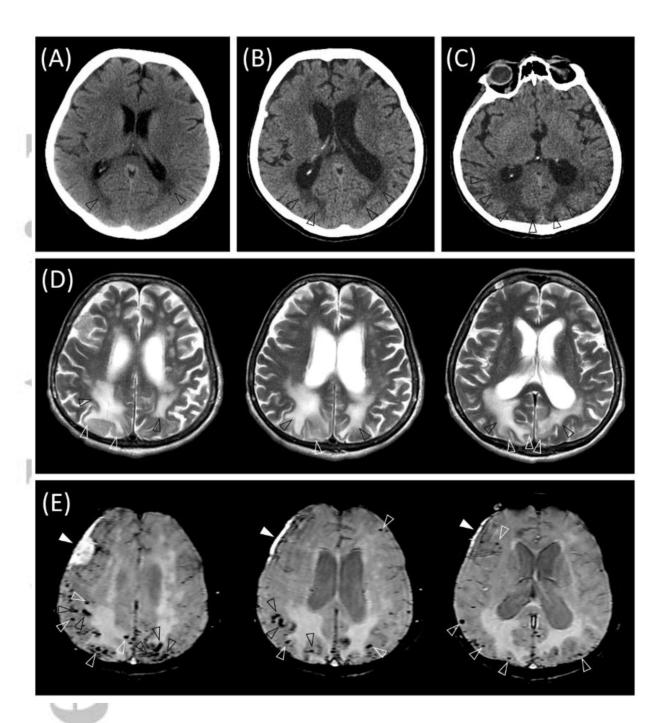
Imaging of Case 2. Minor bioccipital periventricular lucencies (arrowheads) 7 years before presentation (A). Increased atrophy and a moderate increase in bioccipital WMHs (arrowheads) at first seizure (B). The dramatic expansion of the occipital-parietal WMHs with right-sided predominance (arrowheads) 2.5 months later (C). MRI T2 demonstrates asymmetric confluent WMHs (black hollow arrowheads) with focal cortical involvement (white hollow arrowheads, D) and associated CMBs and CSSs (a few examples marked with white and black hollow arrowheads, respectively) on SWI (E). A right frontal meningioma with a dural tail is apparent (white-filled arrowheads in E).
